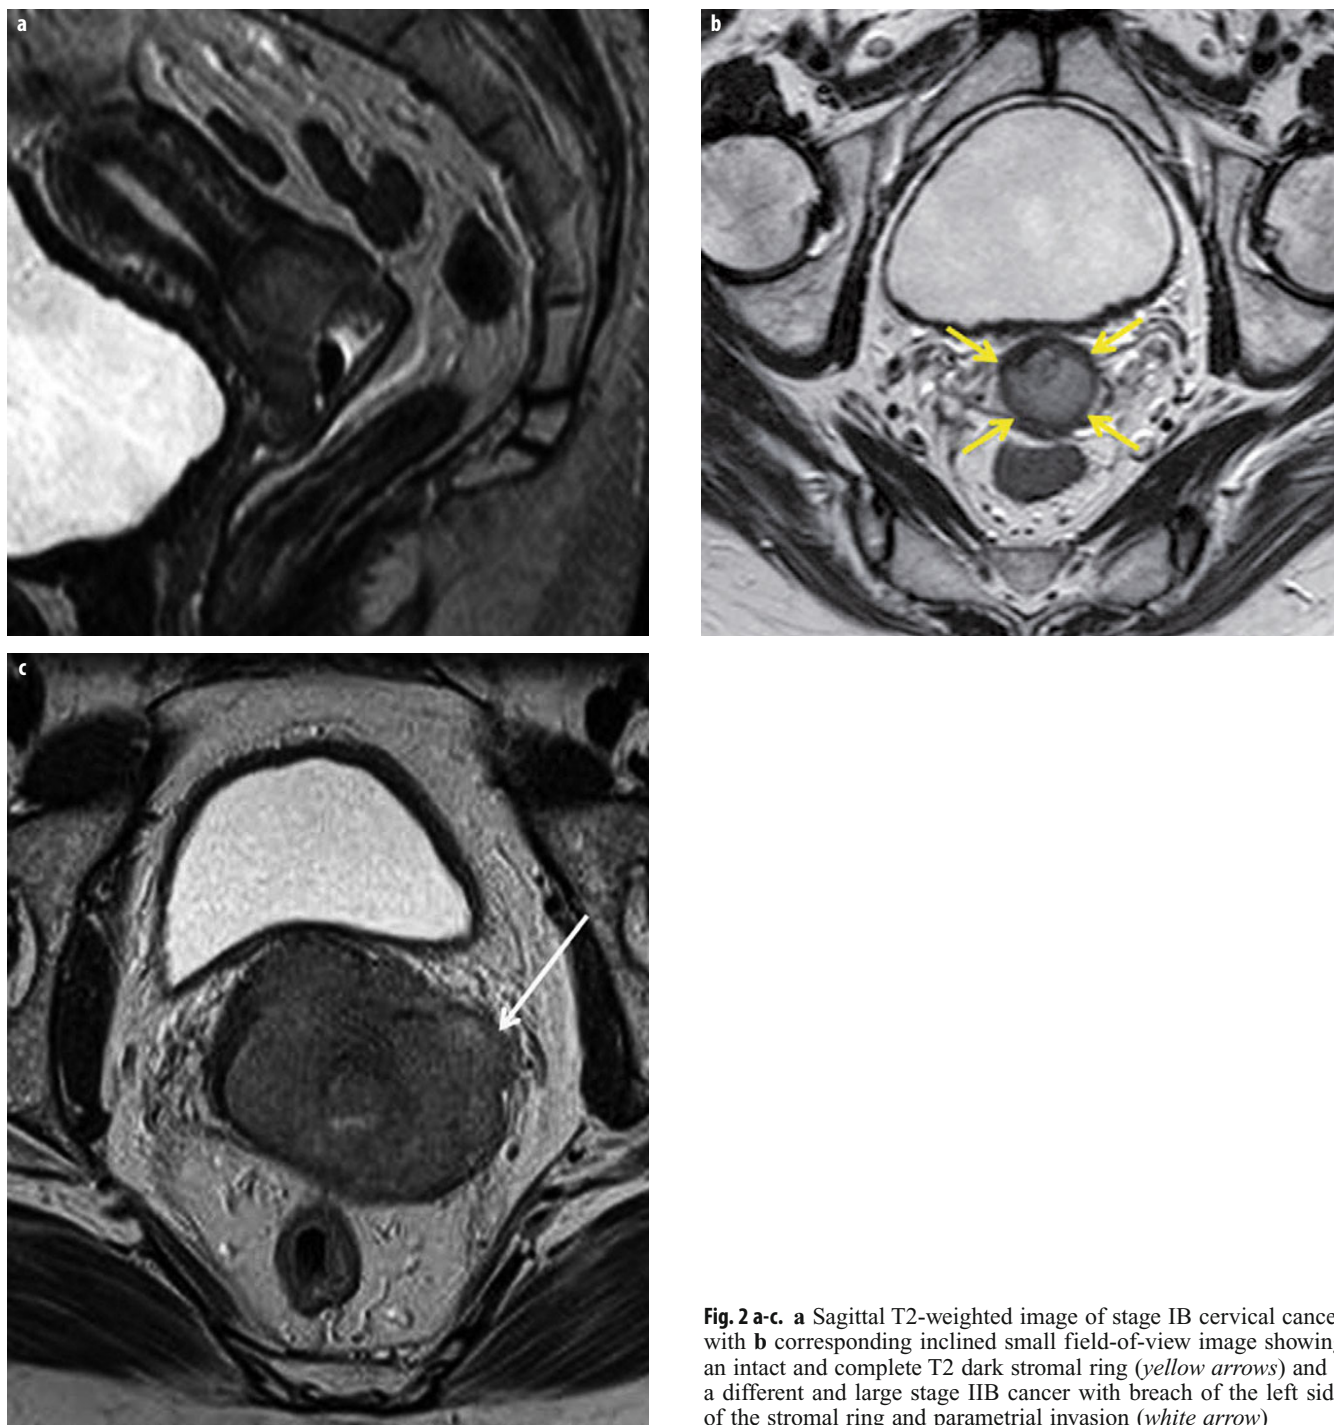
a-c. a Sagittal T2-weighted image of stage IB cervical cancer with b corresponding inclined small field-of-view image showing an intact and complete T2 dark stromal ring (*yellow arrows*) and c a different and large stage IIB cancer with breach of the left side of the stromal ring and parametrial invasion (*white arrow*)
